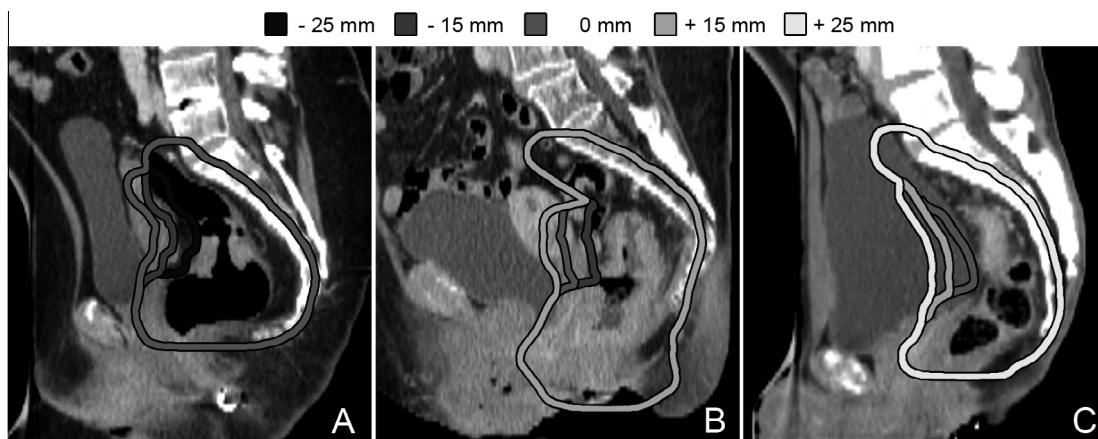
Examples of possible margin selections. (A) for a patient with a full rectum and empty bladder on the planning CT scan, margins of -25 mm, -15 mm and 0 mm were used. (C) shows the opposite anatomy (full bladder and empty rectum) which warrants margins of 0 mm, 15 mm and 25 mm, and (B) shows a mixed situation for which margins of -15 mm, 0 mm and 15 mm were used. Patients were treated in prone position on a belly board (A + C), or in supine position (B).
